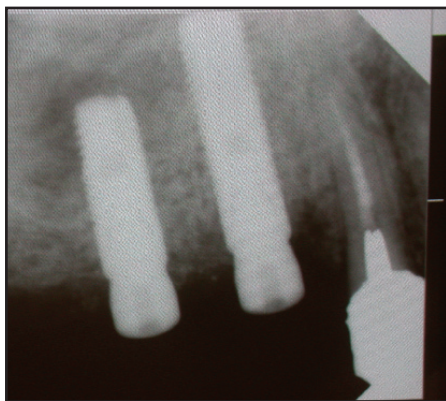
a radiograph taken at this visit (four-month second surgical stage)
